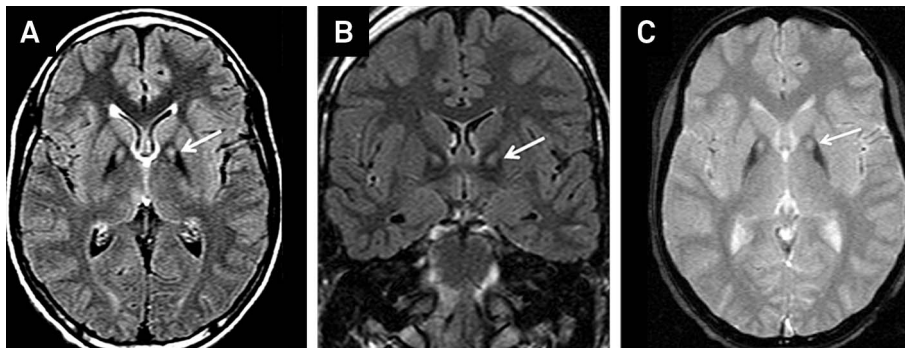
Axial FLAIR (A), coronal FLAIR (B) and spin echo (C) sequences brain MRI disclose marked hypointense signal of the globus pallidus with central hyperintense signal (eye-of-the tiger appearance) (arrows).
